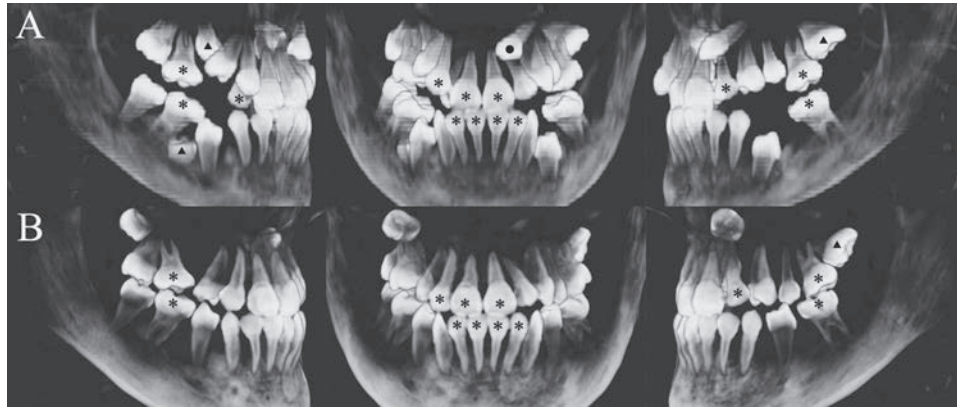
Cone-beam computed tomography. A, pre-treatment (age: 12 years and 4 months). B, Post-active treatment (age: 19 years and 11 months). * = short V-shaped root, ▲ = impaired root development, ● = impacted tooth.
